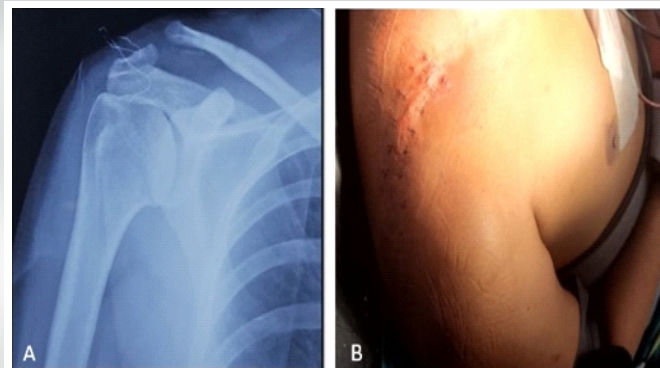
Image series showing the X-ray of the right shoulder antero-posterior view (a) and clinical picture (b) showing the first stage of surgery with the implant removed and stitch line dry and healthy without any sign of infection.
